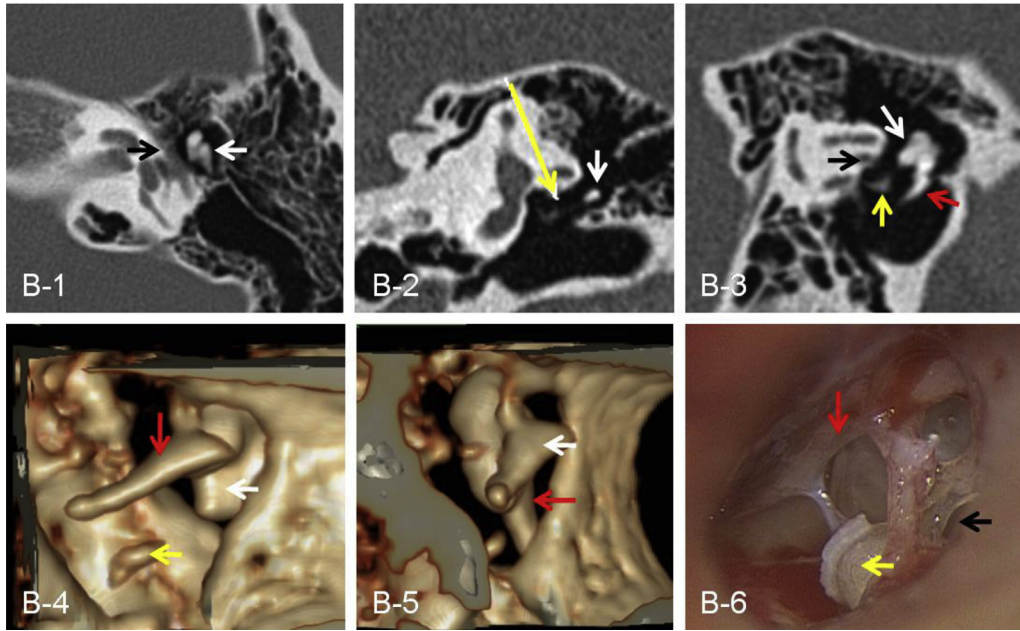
B-1: axial section plane of CT; B-2 coronal section plane of conventional CT; B-3:MPR imaging; B-4 and B-5: CTVR imaging; B-6: Surgical image. Red arrow—hand of malleus; white arrow—body of incus; black arrow—facial nerve; yellow arrow—abnormal stapes superstructure.
